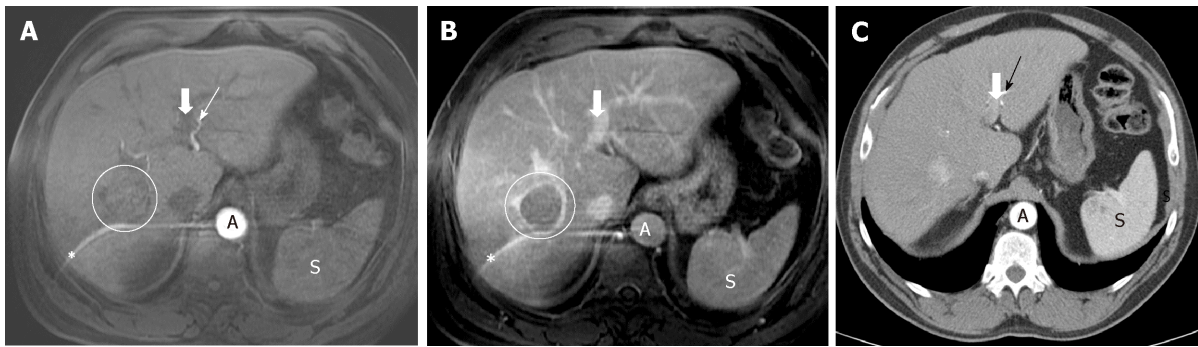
Importance of precise late arterial phase. A: Too early arterial phase. Aorta and left hepatic artery (thin arrow) with high signal intensity, but no contrast is seen in portal vein (thick arrow). No contrast in the suspicious lesion; B: Late venous phase: washout and capsule in the lesion (but no diagnoses due to lack of hyperintensity in arterial phase due to bad technique). Note the artifact in MRI images (*); C: CT was performed in the same patient with a good late arterial phase depicting hyperattenuation of the lesion that it is now diagnostic. Contrast in left portal vein can be seen (thick arrow).
